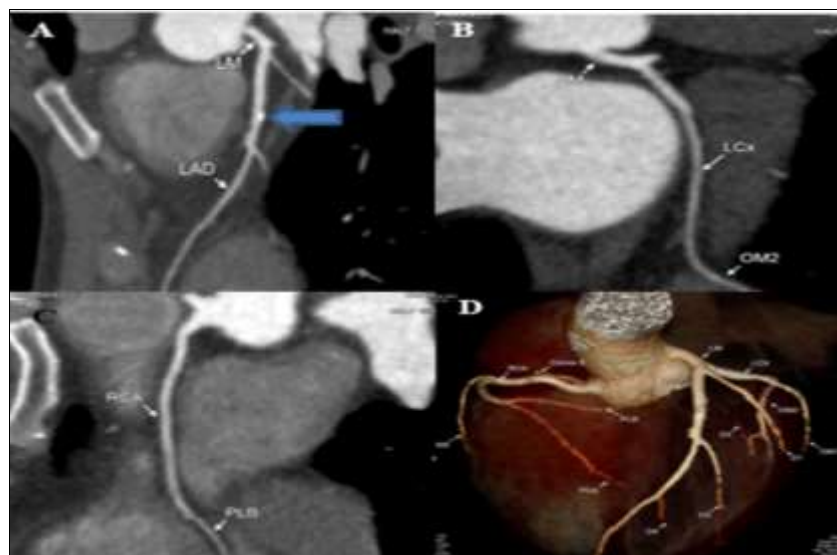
CT coronary angiography. (A): Curved MPR image showed an eccentric calcified plaque (blue arrow) at LAD mid segment & exerting minimal stenosis about 20% for about 6 mm, (B): Curved MPR image showed good opacification of LCx and OM branch, No coronary stenosis, (C): Curved MPR image showed good opacification of RCA, No coronary stenosis, (D): 3D VR showed normal coronary arteries
